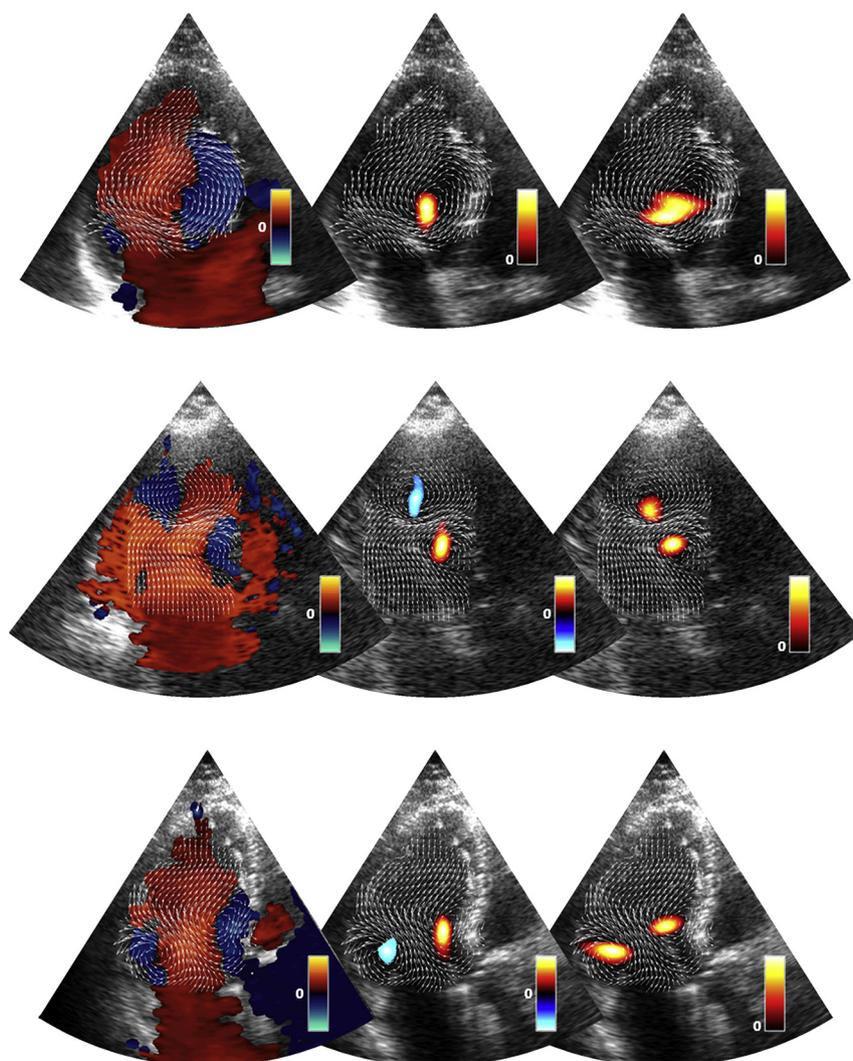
Vector flow mapping (VFM) and Doppler vortography in three patients. The first column represents vector flows, as measured by the VFM technique described by Garcia et al. (2010), superimposed on conventional color Doppler images (the color bars represent Doppler velocities). In the second column are blood vortex signature (BVS) maps. High BVS amplitudes denote the presence of a large-scale vortex. The BVS sign represents the direction of rotation (see eqn [3]). The vector flows measured by VFM are also displayed for comparison purposes. The third column represents the Okubo-Weiss criterion derived from the VFM vector velocity fields. The Okubo-Weiss criterion is positive in zones of high vorticity. Note how well zones of high-amplitude BVS compare with this criterion. The images in the first row are from a normotensive subject with normal echo.
